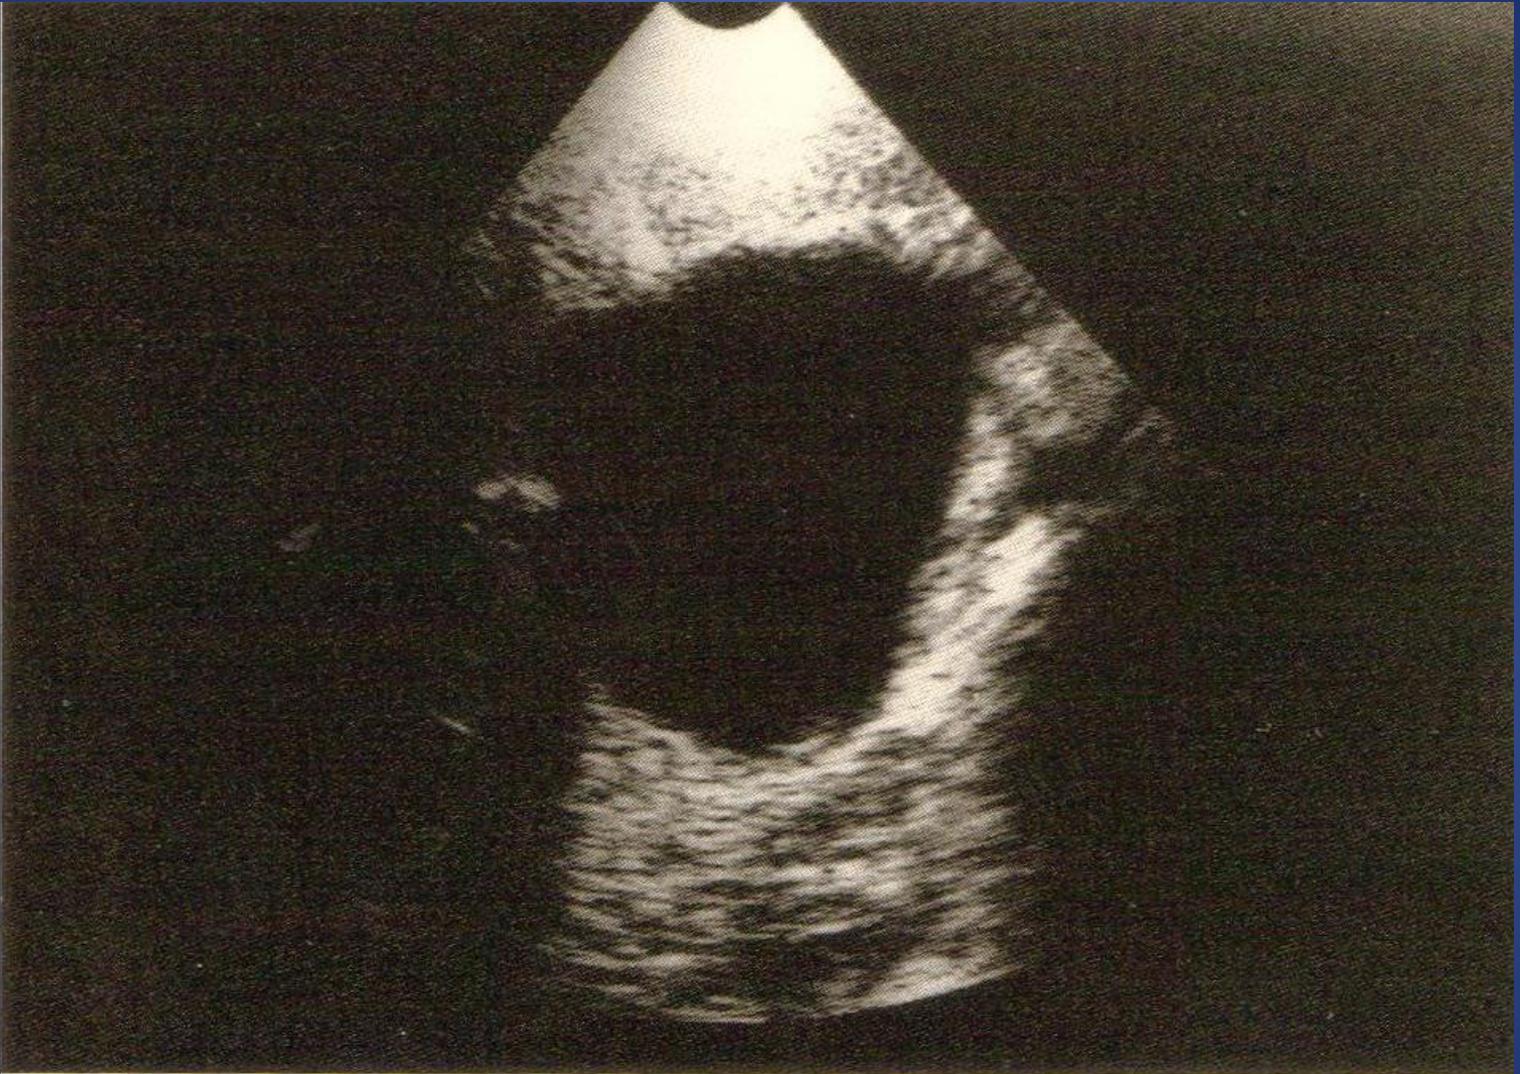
Ultrasonography of choledochal cyst.
